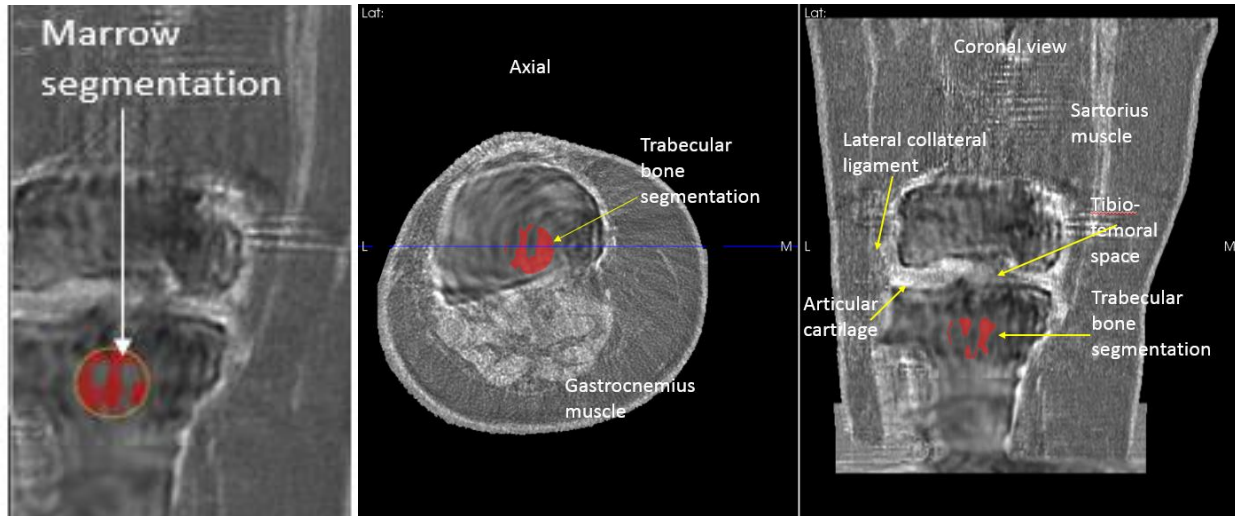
Left to right: Coronal view, with marrow segmentation shown in red. Axial and coronal view of cadaver knee 3D ultrasound speed of sound image (SOS) with bone segmented region shown in red. This has an average SOS = 1466 m/s (SD = 29.9) which agrees with estimates of slow P wave SOS in human femur at 0.4 – 0.8 MHz.
